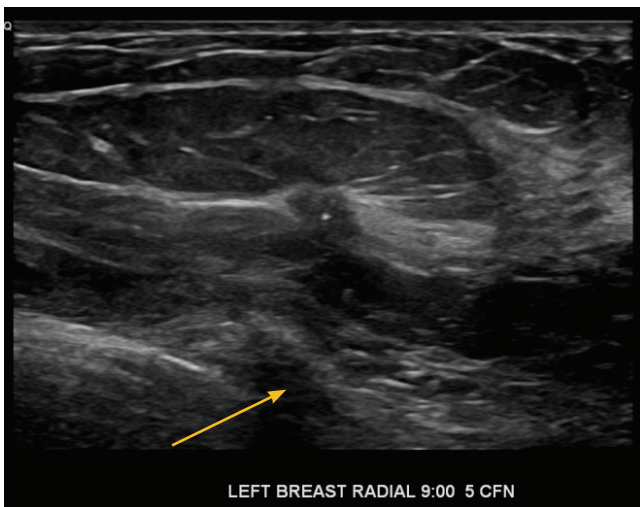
Case 1: L9N5 9 mm mass confirmed on ultrasound. Pathology: Well-differentiated Invasive Ductal Carcinoma and low-grade Ductal Carcinoma In Situ.
